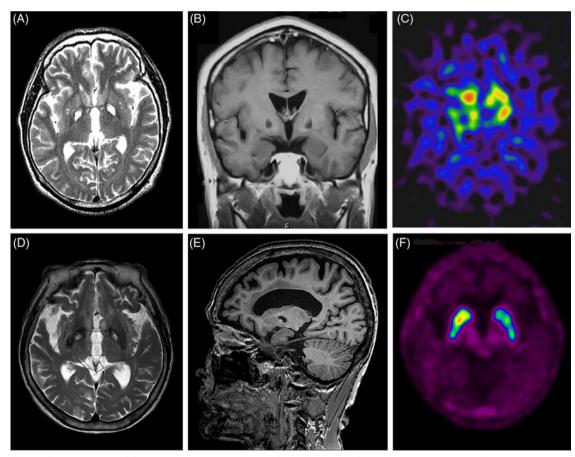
Brain MRI and dopamine transporter imaging of case 1 (A-C) and case 2 (D-F). Brain MRI shows cystic necrosis of the GPi and GPe in both patients. Dopamine transporter imaging (^{123}I -FP-CIT SPECT in case 1 and 18 F-FP-CIT PET in case 2) shows decreased FP-CIT uptake in the bilateral striata, which is more severe on the left side in case 1 and on the right side in case 2. (A) Case 1 T2. (B) Case 1 T1. (C) Case 1 FP-CIT SPECT. (D) Case 2 T2. (E) Case 2 T1. (F) Case 2 FP-CIT PET
